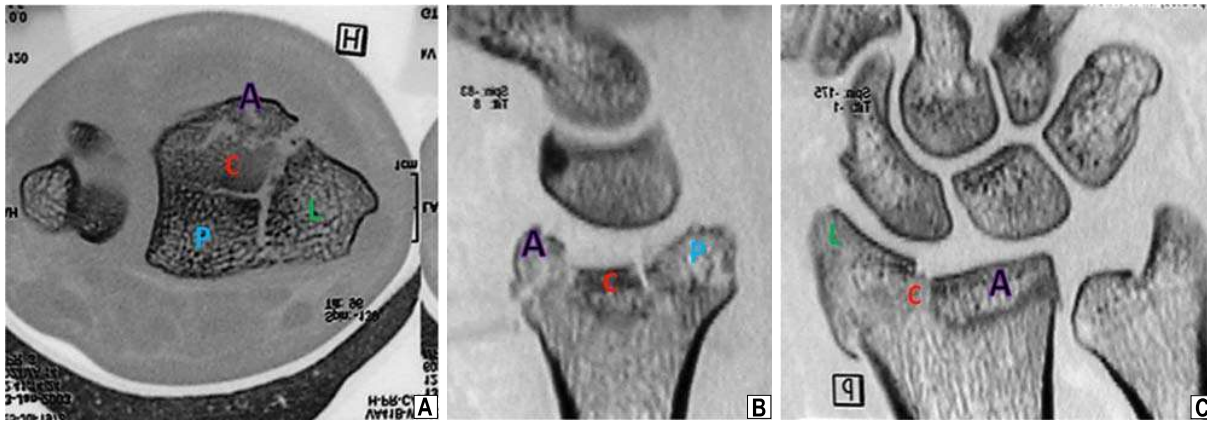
CT-scan of a complex distal radius fracture based on the CLAP concept.
